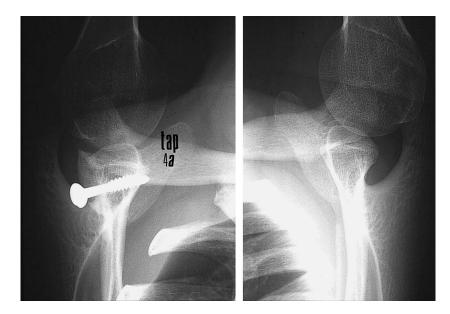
X-ray view of a posterior bone block with a follow-up of 4 years (left) compared with the controlateral shoulder (right). The lateral extension of the graft enlarges smoothly the glenoid articular surface posteriorly. Humeral head appears to be quite recentered compared to the other side.
